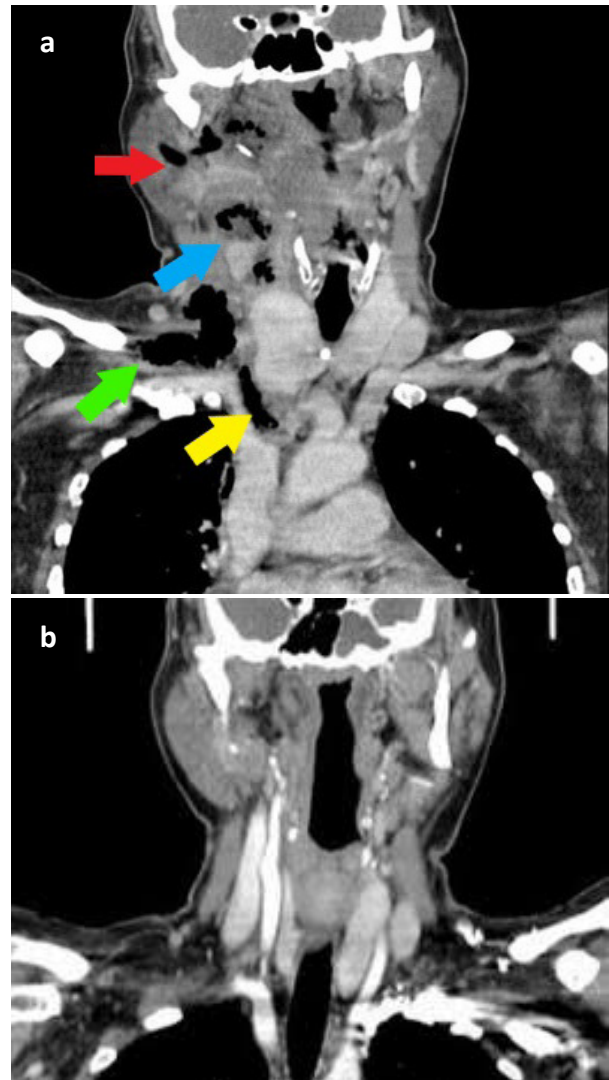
Contrast-enhanced coronal neck CT imaging shows a) a deep neck abscess with air bubbles, starting from the parotid cavity (red arrow), extending to the parapharyngeal and visceral space inferiorly (blue arrow), which opened to the danger space and spread to the mediastinum (yellow arrow); the swelling starting under the clavicle in the physical examination (green arrow). b) In the coronal plane tomography image of the patient three months later, the abscess areas in the neck and mediastinum were completely healed and had a natural appearance.
